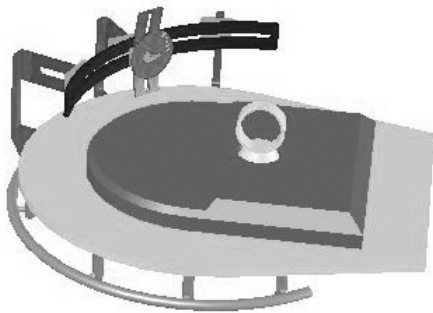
The 3D MRI-compatible knee loading device mounted to the patient table. The slide rails and rotation disc permit knee rotation in the three planes.
